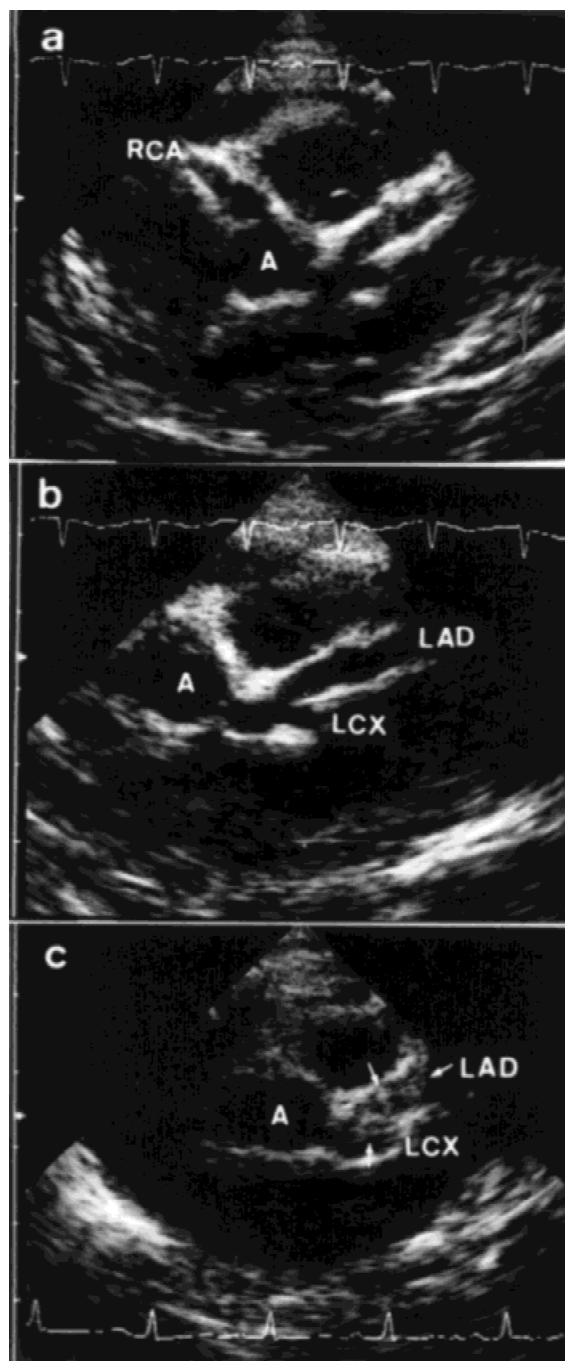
Two-dimensional echocardiographs (2-DE) performed on the 15th day (a,b) and 29th day (c) following the onset of symptoms. The 2-DE on the 15th day demonstrated large coronary aneurysms in the bilateral coronary arteries, but without evidence of thrombus. However, several thrombi (arrows in c) were detected in the left coronary artery on the 29th day. A, aorta; LAD, left anterior descending artery; LCX, left circumflex artery; R, right coronary artery.
